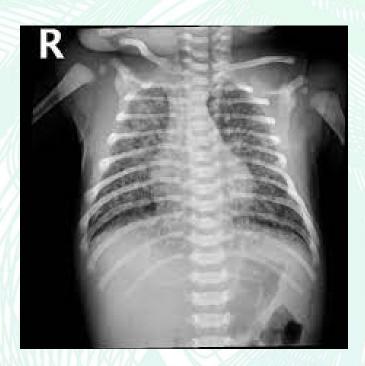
Chest x-ray of Meconium aspiration syndrome (MAS)
